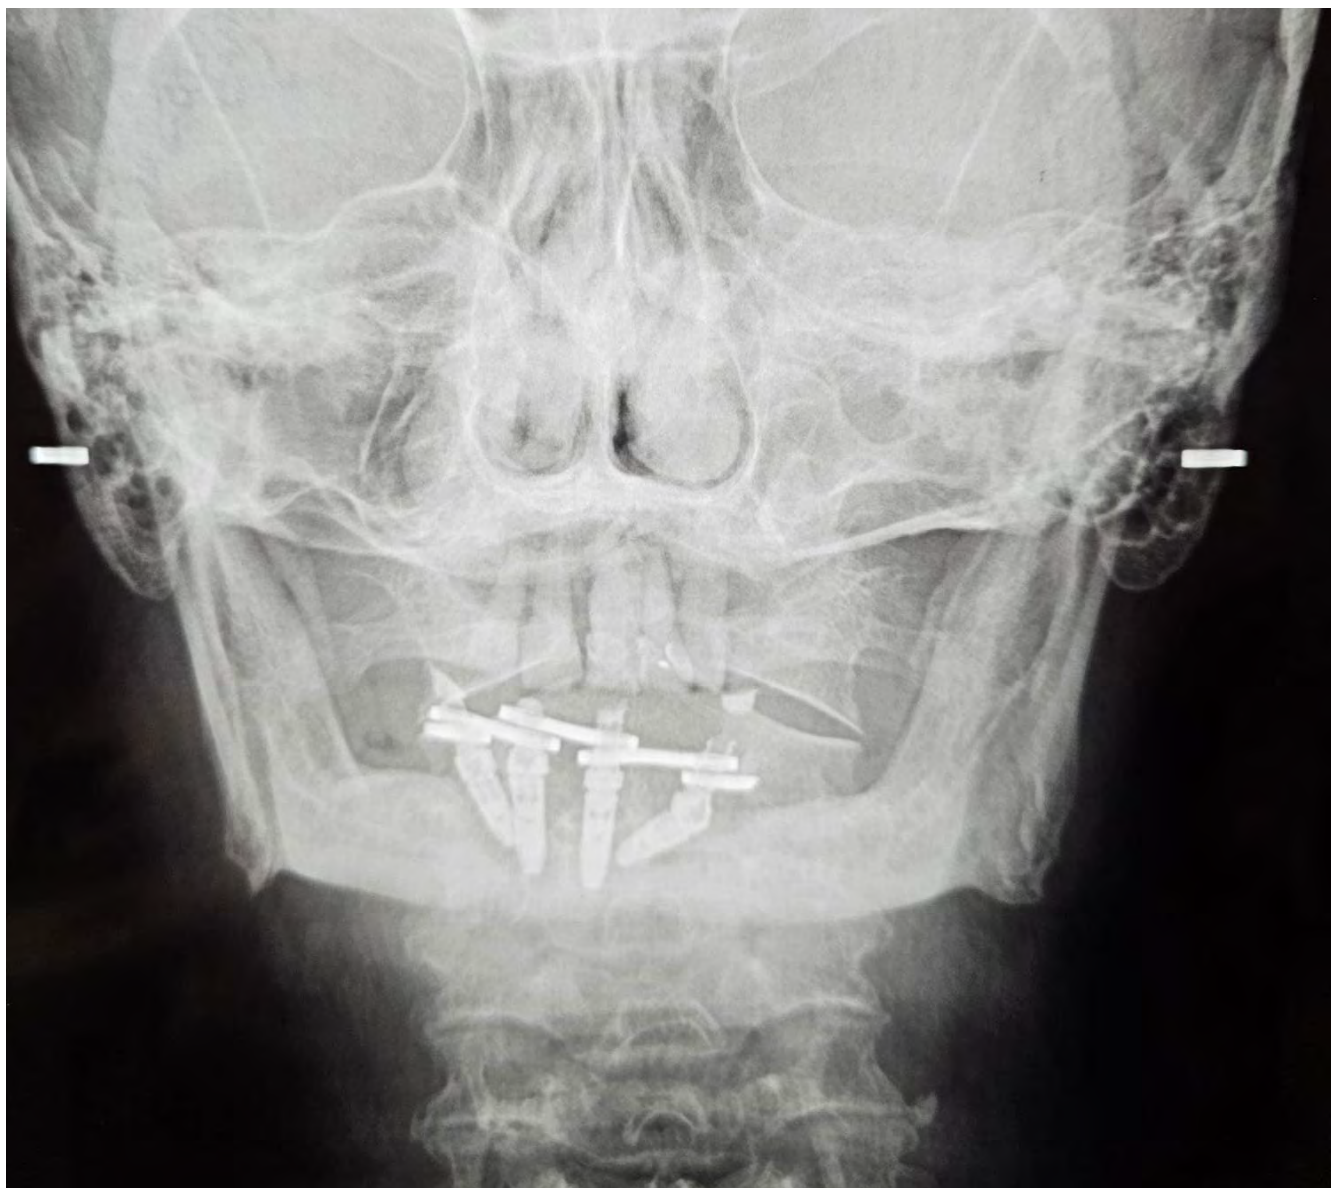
PA radiograph of the skull of our patient, showing massive bone loss and a reduced vertical dimension.
